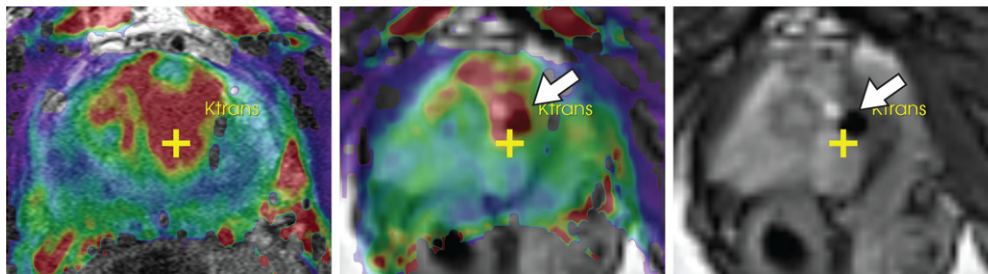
Example MR images from one clinical case. A target point was defined within the central gland with a high value in the K^{trans} pharmacokinetic parameter map registered and overlaid on the intraprocedural T2w image (left). The needle placement was confirmed by the artifact shown on the real-time TurboFLASH MR image (indicated in the middle and right images).
